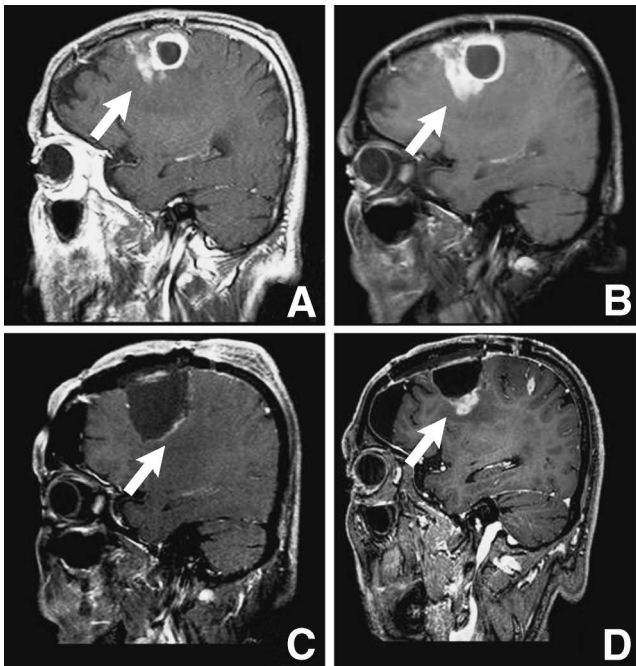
Case 2. A 33-year-old man with secondary glioblastoma multiforme lesions (arrows) in the bilateral frontal lobes and corpus callosum. Serial T<sub>1</sub>-weighted magnetic resonance images with gadolinium demonstrating dramatic decrease of the enhanced area (A: before the 2<sup>nd</sup> operation, B: after the 2<sup>nd</sup> operation, C: 5 weeks after autologous formalin-fixed tumor vaccine [AFTV]/ temozolomide [TMZ] therapy, D: 12 weeks after AFTV/TMZ therapy), and regrowth of the tumor (E: 20 weeks after AFTV/TMZ therapy).
